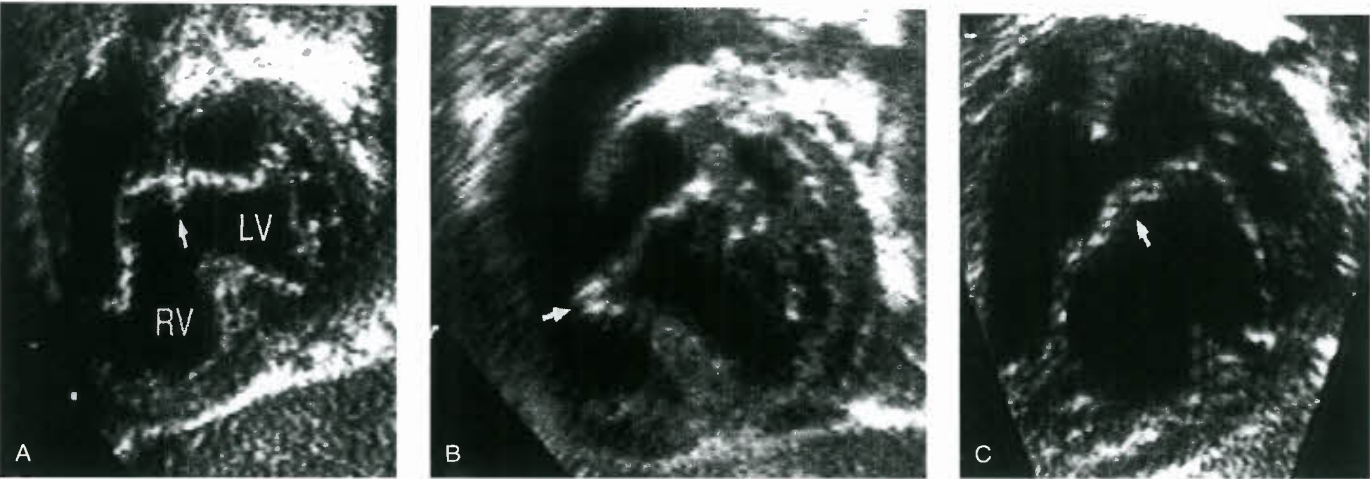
Anatomic and echocardiographic features of complete AVSD based on the Rastelli Classification. A: Type A complete AVSD. The defect is characterized by insertion of the anterior bridging leaflet to the crest of the ventricular septum (VS). B: Type B complete AVSD. The defect is characterized by dominant insertion of the anterior leaflets into papillary muscles in the RV. In this example, the anterior bridging leaflet inserts onto the crest of the ventricular septum, as well as onto a large ventricular papillary muscle (P) (arrow in echocardiogram). C: Type C AVSD. The anterior leaflet is unattached (arrow) and overrides the crest of the ventricular septum. The free anterior leaflet does not insert onto the crest of the ventricular septum. A, anterior; P, posterior; L, left; LA, left atrium; LV, left ventricle; R, right; RA, right atrium; S, superior. (Modified from Seward JB, Tajik AJ, Edwards WD, et al. *Two-Dimensional Echocardiographic Atlas. Vol. 1. Congenital Heart Disease.* New York, NY: Springer-Verlag, 1987:270–292, with permission.)
